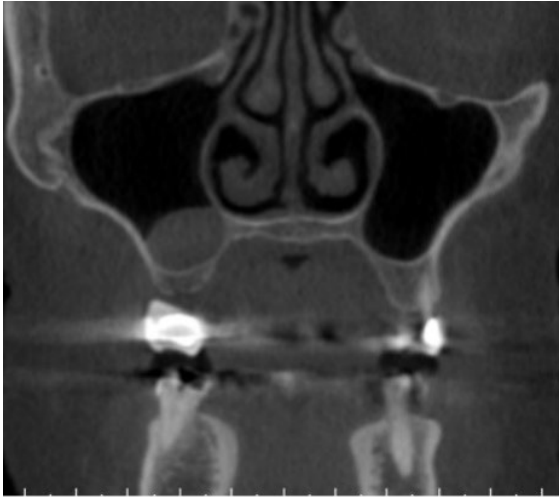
Coronal CBCT cut showing polyp in the right maxillary sinus.
